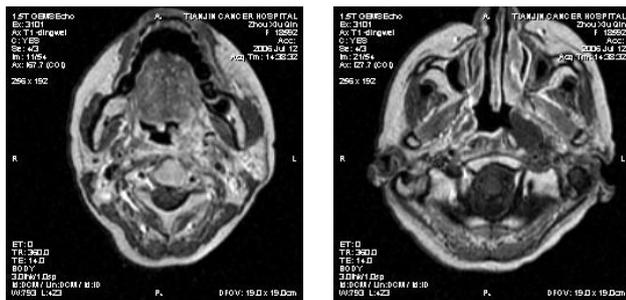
CT image of oral pharynx, nasopharynx and cranial base of the patient.
